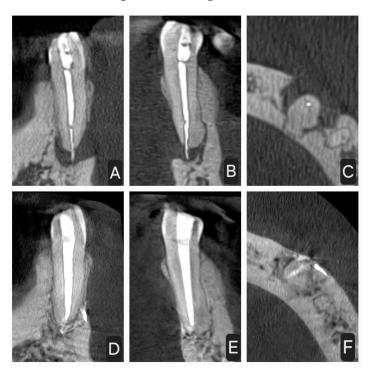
CBCT images of tooth 3.3. Coronal, axial, and transverse CBCT views at pre-treatment (A–C) and post-treatment (D–F). The apical lesion initially measured $10 \times 9 \times 8$ mm. A clear recovery of trabecular and buccal cortical bone can be observed, when comparing images C and F, after using conventional endodontic therapy combined with laser therapy in both its aPDT and PBMT modalities.
